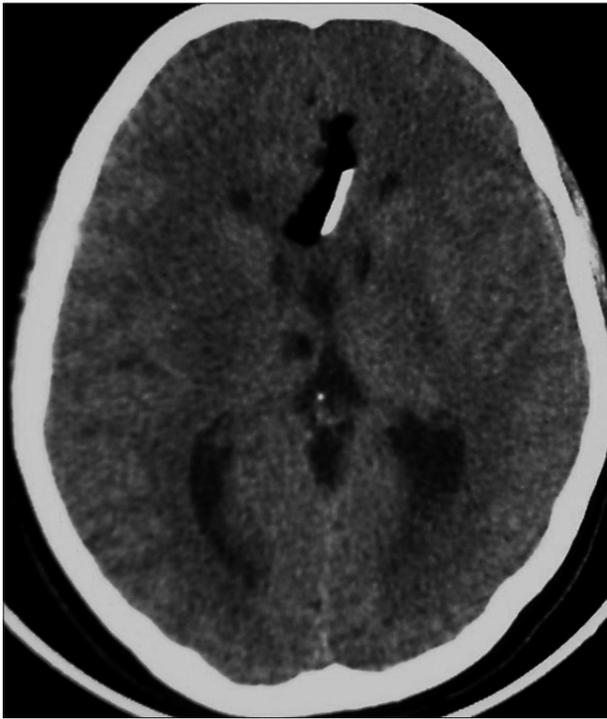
Axial CT scan: interhemispheric hypodense area containing calcific component.
